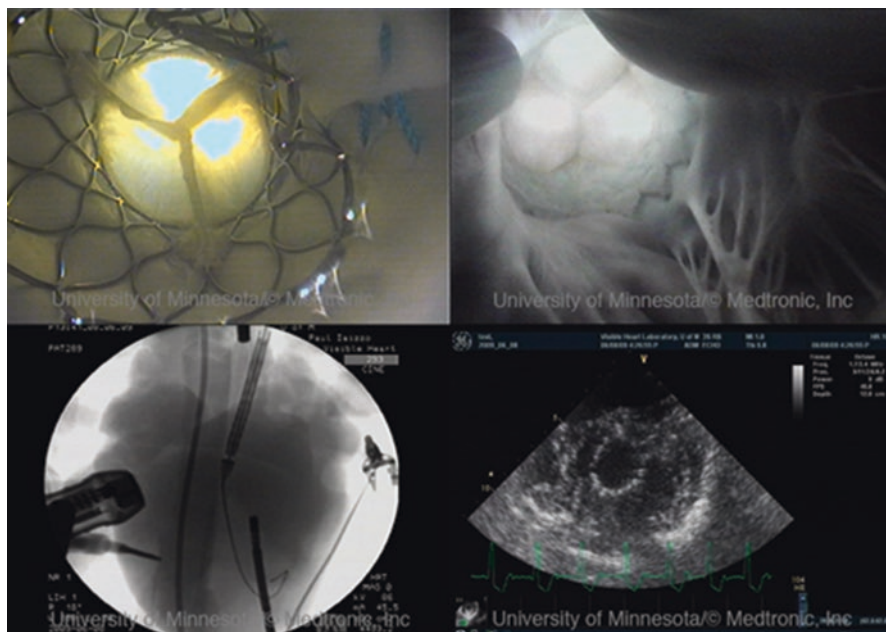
Images of a transcatheter-delivered aortic valve imaged using the following: (1) an endoscope placed within the ascending aorta (upper left panel), (2) an endoscope placed within the left ventricle (upper right panel), (3) fluoroscopy with an anterior-posterior orientation (lower left panel), and (4) ultrasound (lower right panel). (Modified from Iazzo et al. [34])
